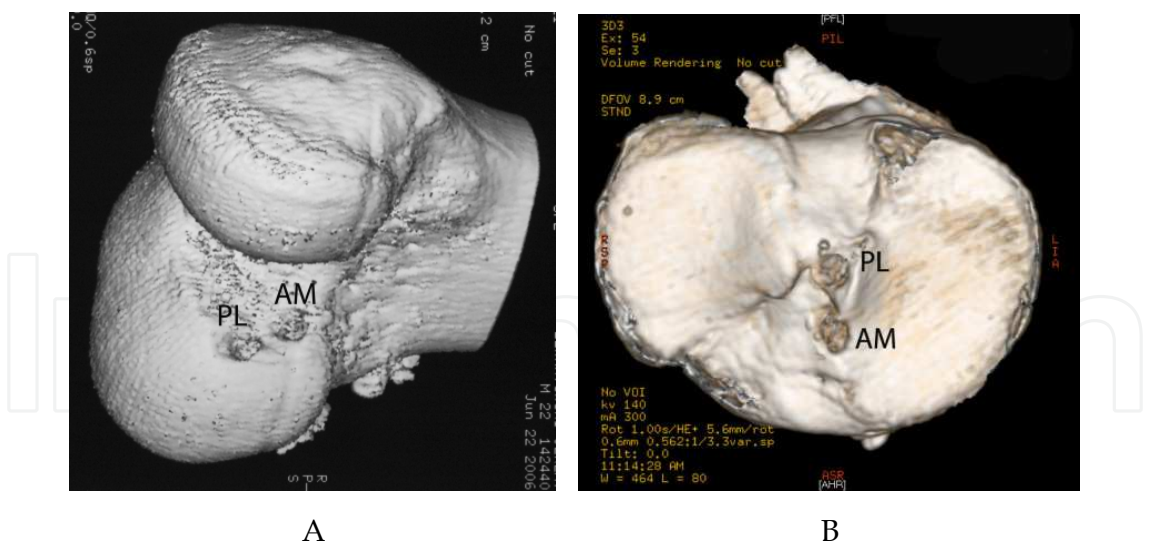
Three-dimensional CT scan views of the tunnels after double-bundle AC reconstruction. A: femoral sockets, B: intra-articular aperture of the tibial tunnels.
